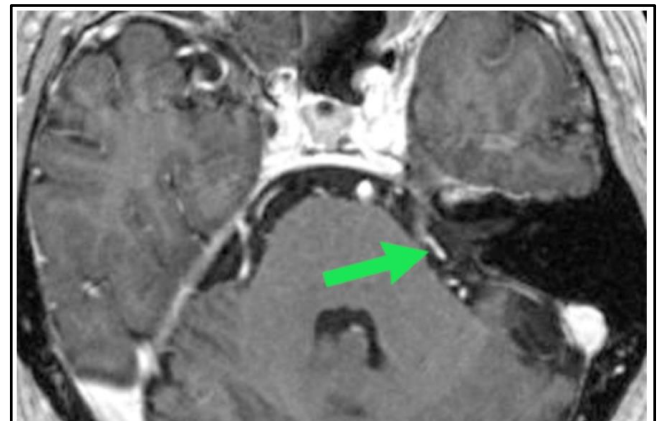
MRI scan showing a blood vessel (arrow) compressing the trigeminal nerve (Source: Mayfield Brain & Spine, 2016)
